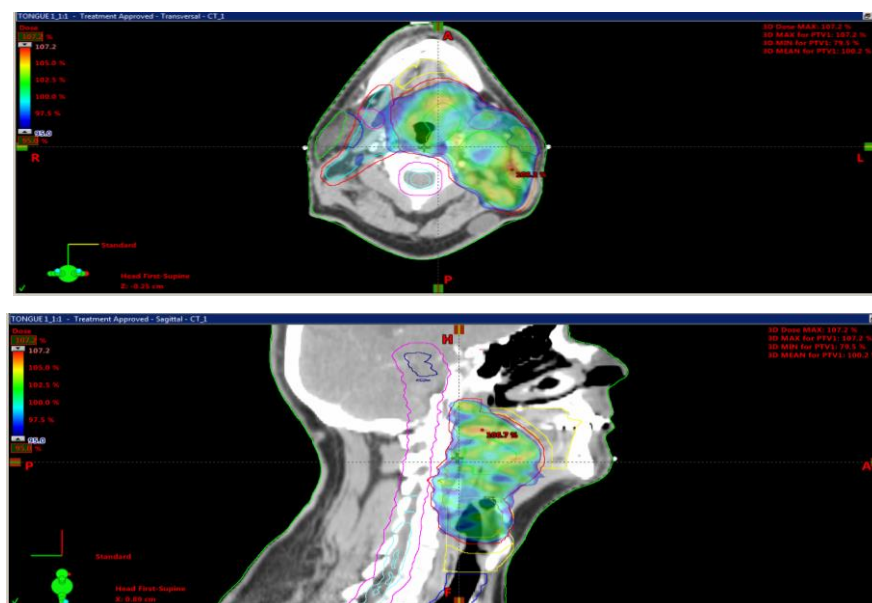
Screen shot of radiation treatment plan on axial and sagittal CT for radiotherapy treatment of base of tongue (BoT) tumour on Eclipse treatment planning software (Courtesy of The Beatson West of Scotland Cancer Centre, Glasgow)
